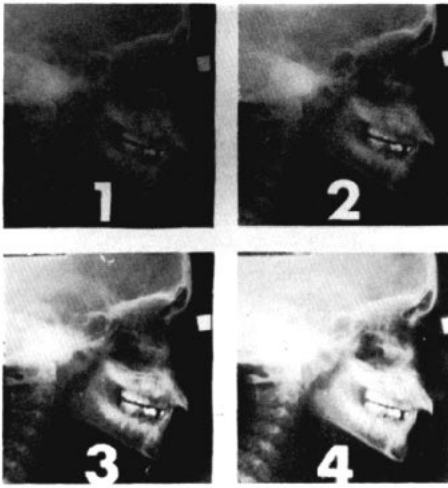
This series of radiographs form a "grey scale" which is used for comparison to determine the exposure time for any radiograph to be copied.
